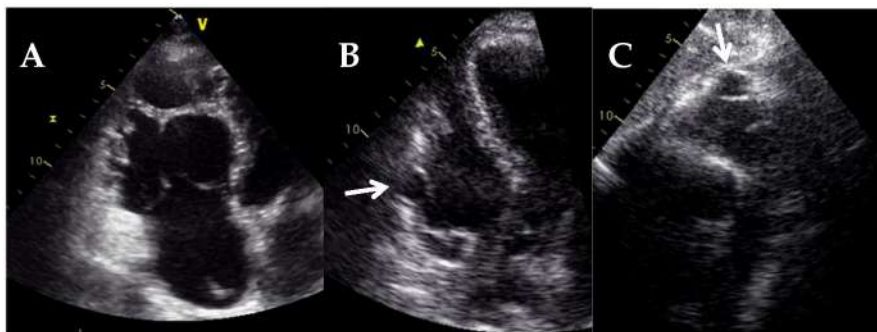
Transthoracic echocardiography of a patient with right ventricular arrhythmogenic cardiomyopathy. (A) RV dedicated apical 4-chamber view shows severe dilatation of the RV. RV dedicated apical 4-chamber view (B) and subcostal view (C) show the presence of aneurysms in the RV free wall (arrow).
